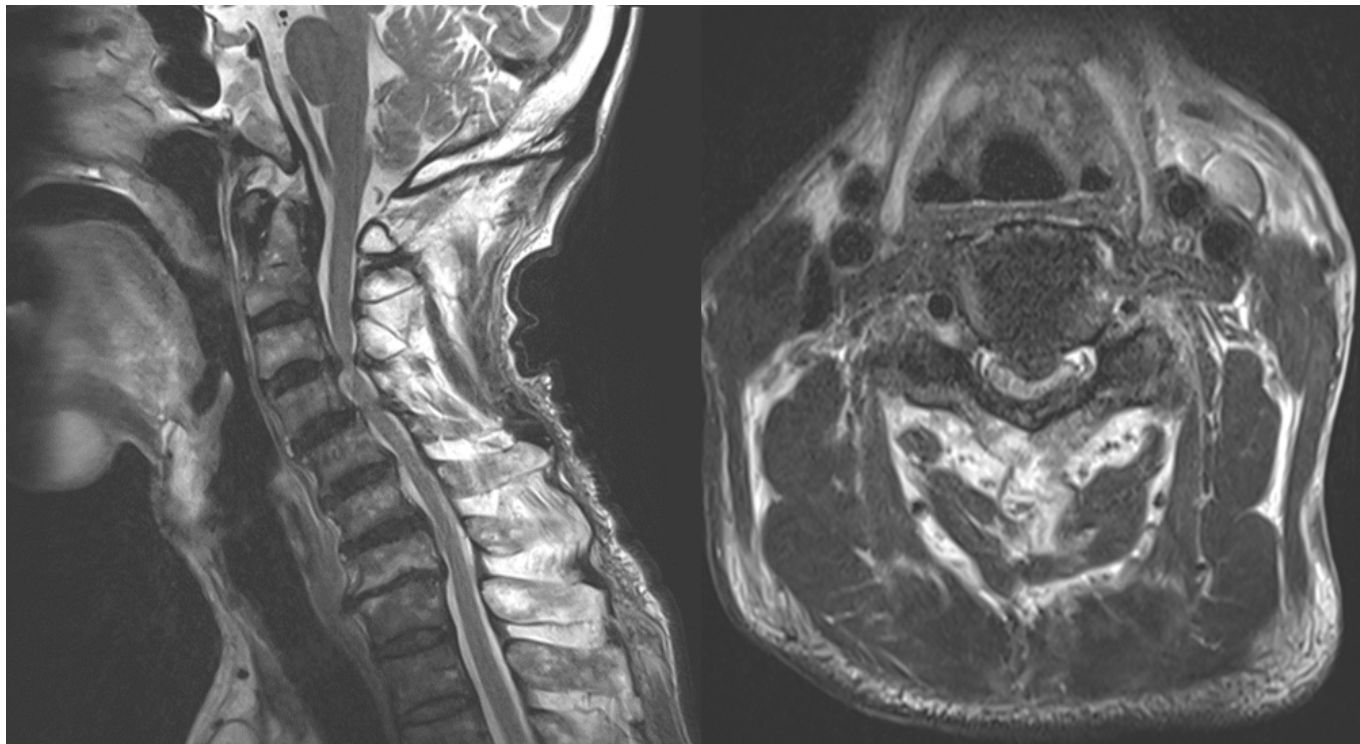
The preoperative magnetic resonance imaging revealed severe stenosis with herniated nucleus pulposus at the C3-4 level, leading to cord compression and signal changes. This level was assessed as the symptomatic lesion, prompting the decision to proceed with anterior cervical discectomy and fusion surgery.
